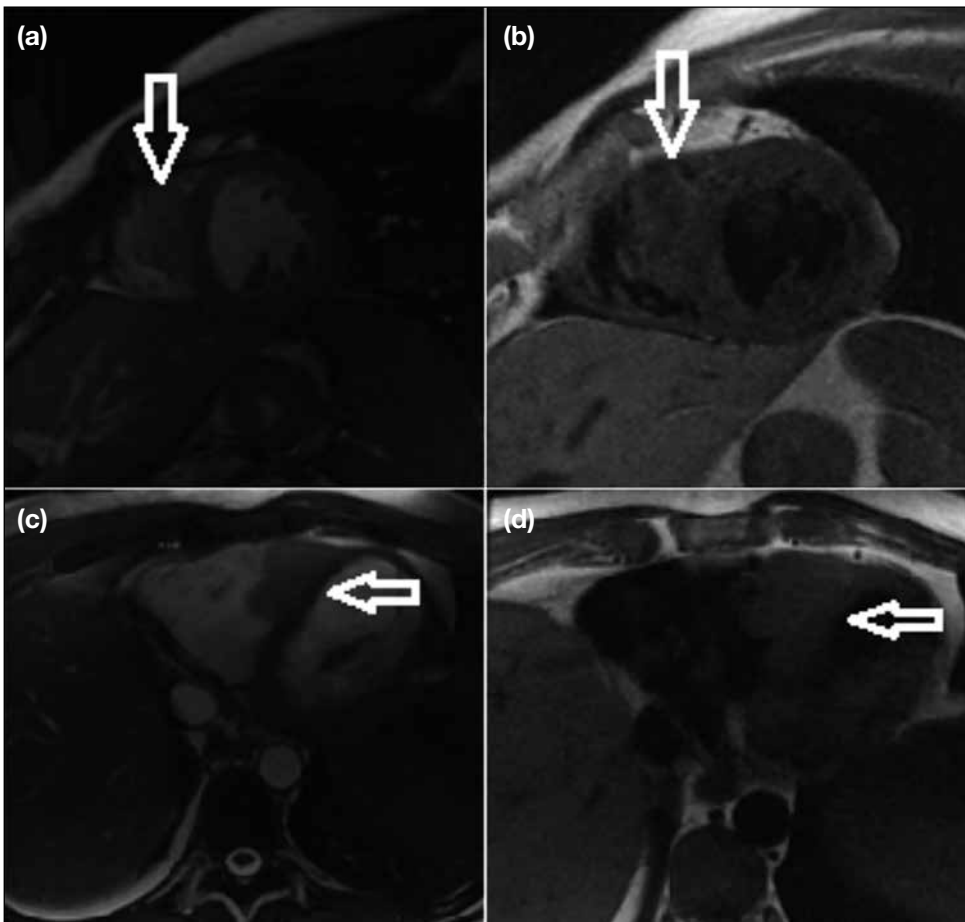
Cardiac magnetic resonance imaging of a 28-year-old male patient with a history of non-Hodgkin lymphoma. The patient was treated with both chemotherapy and radiotherapy in childhood and was later diagnosed with high-grade iliopsoas leiomyosarcoma. The images showed the same lesion at different sequences and projections, which is a mass arising from the interventricular septum with a broad base extending into the right ventricular chamber (arrows), consistent with a metastasis from the leiomyosarcoma. (a) Short-axis cine steady-state free precession gradient echo sequence. (b) Short-axis T1-weighted double inversion black-blood turbo spin echo sequence. (c) Axial steady-state free precession gradient echo sequence. (d) Axial T1-weighted double inversion black-blood turbo spin echo sequence.
